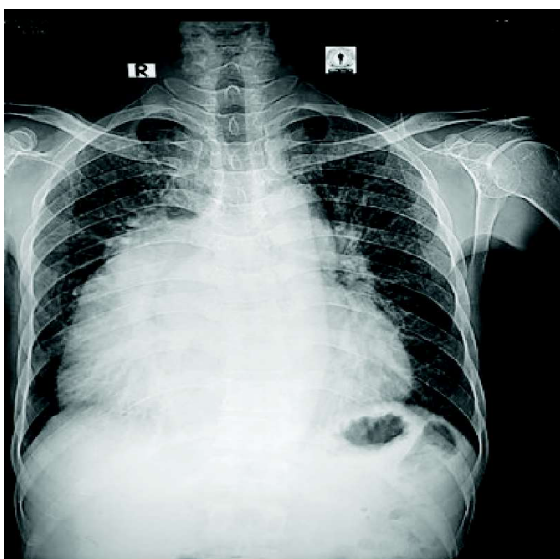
Chest x-ray P/A view shows gross cardiomegaly.
